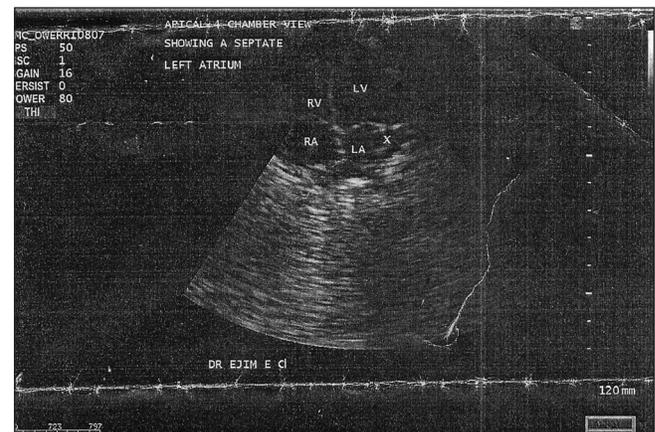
Echocardiogram showing the distal chamber (X) and the left atrium; the right atrium (RA), left ventricle (LV), and right ventricle (RV)
